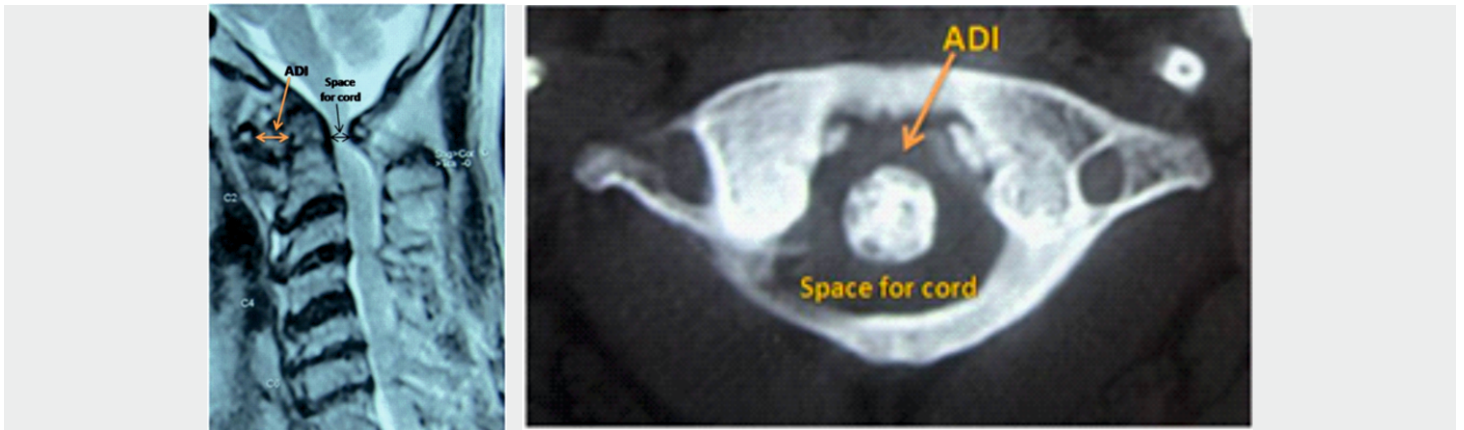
Preoperative CT and MRI of case 3 showing the atlanto axial subluxation with increased atlanto-dens interval (ADI) and consequent decrease in the space available for the cord between the dens and the arch of atlas.
